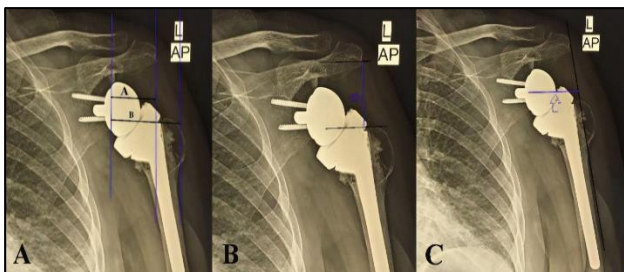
(A-C): Post-operative radiographs showing; AI (A/B), AHD (blue arrow), COR distance from line of pull (blue arrow).
